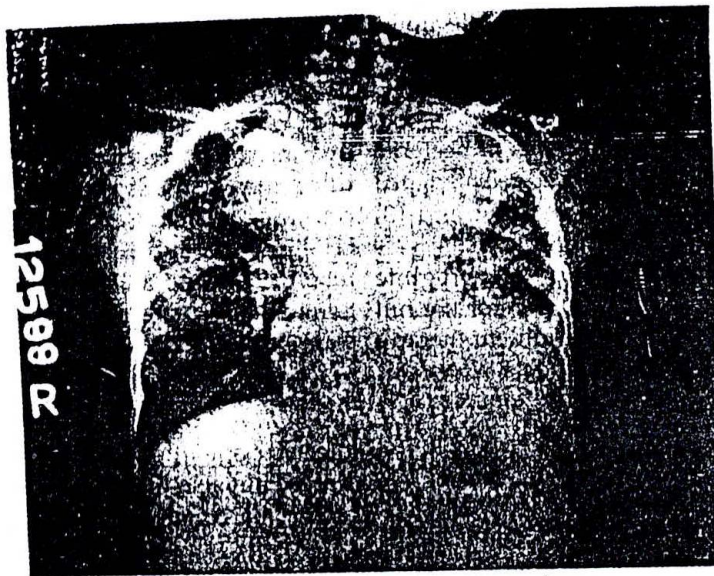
Chest radiograph of a child with tuberculosis and HIV co-infection showing mediastinal lymphadenopathy and lobar infiltrates.
